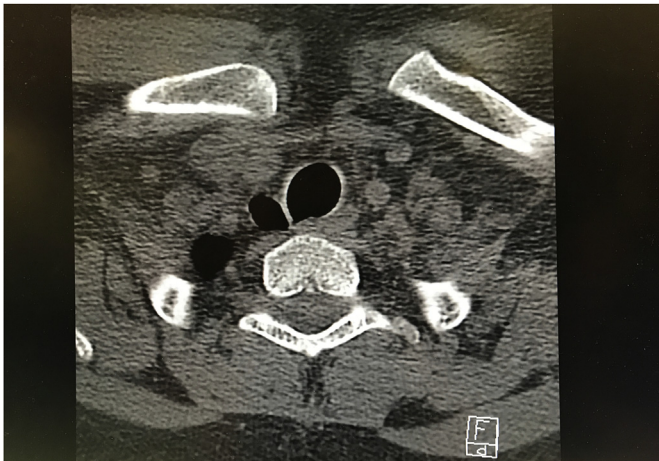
An axial cross section at the level of the thoracic inlet by non-contrast CT. An arrow points to the gas pocket.
